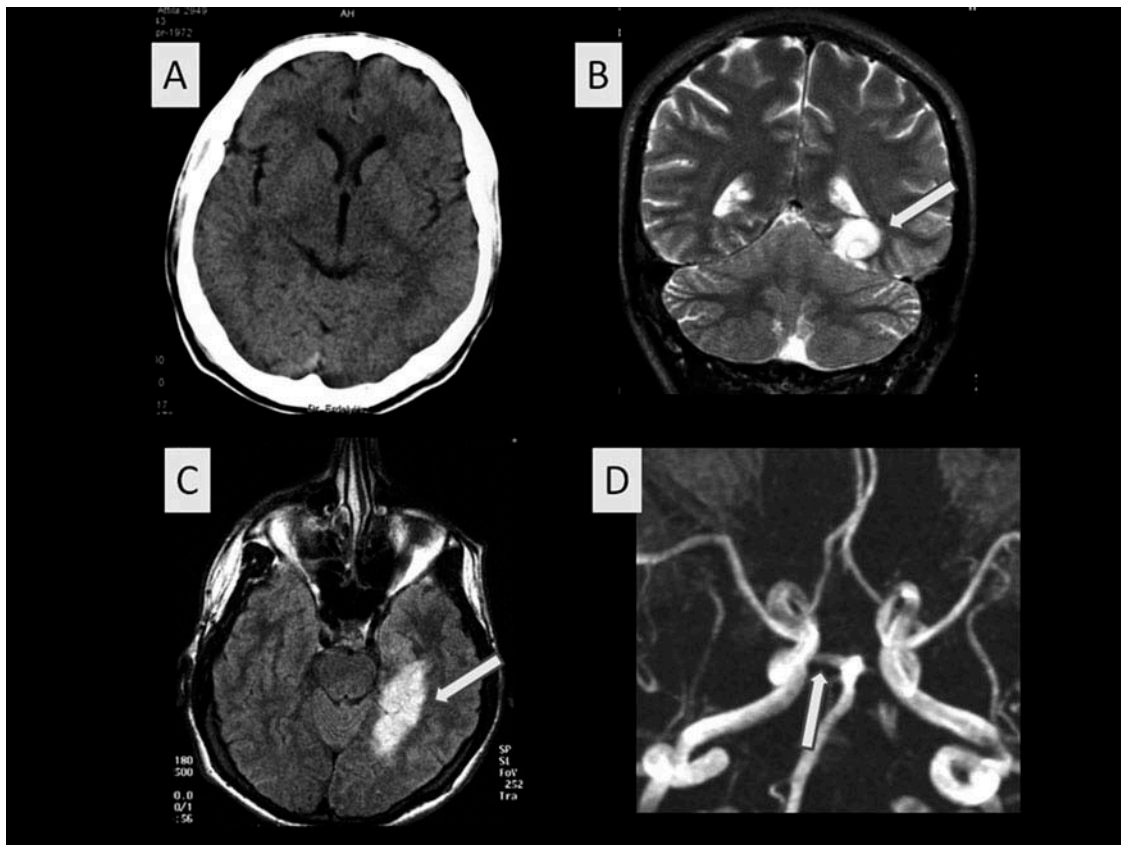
No changes can be seen on the CT image made in the acute phase (A). MRI reveals ischemic lesion restricted to the left hippocampus (B and C, arrows). With MR angiography the right posterior cerebral artery originating from the basilar artery can be clearly seen (D, arrow), but there is no flow in the left posterior cerebral artery.
